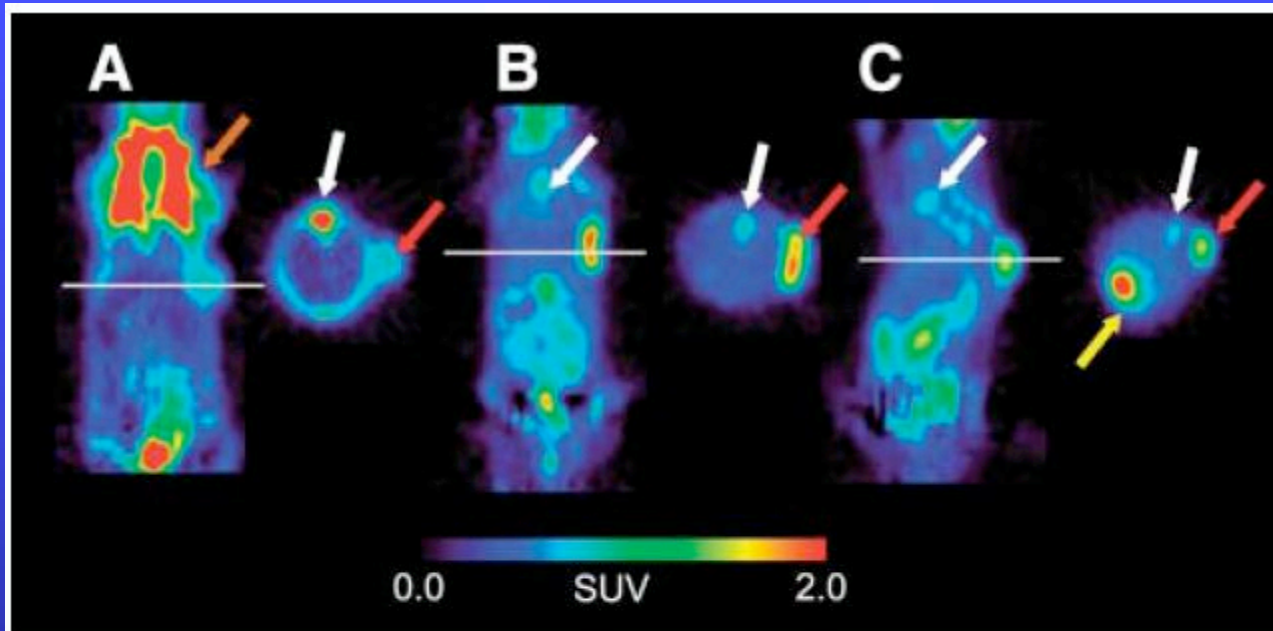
Tumor ^{18}F -FDG uptake under various conditions. Coronal and axial sections are shown. White lines in the coronal sections indicate position of axial sections. (A) Not fasted, not warmed, no anesthesia. (B) Fasted, warmed, no anesthesia. (C) Fasted, warmed, isoflurane anesthesia. Red arrow indicates tumor; brown arrow indicates brown fat; white arrow indicates paraspinal muscle; yellow arrow indicates myocardium.
